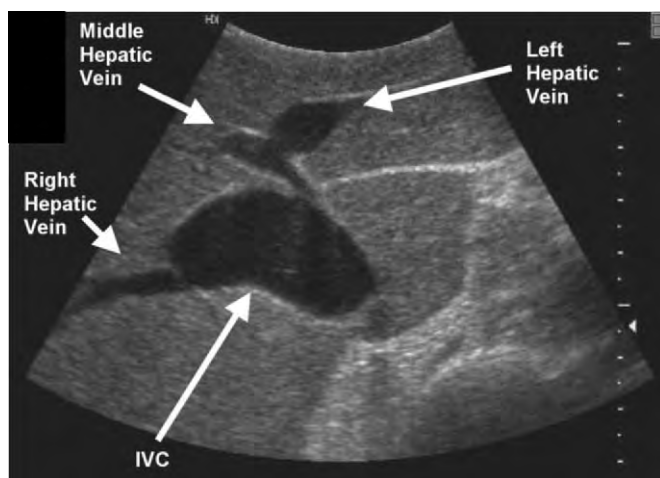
Intraoperative ultrasound image of the three main hepatic veins. The left and middle hepatic veins often join together before emptying into the inferior vena cava (IVC).
